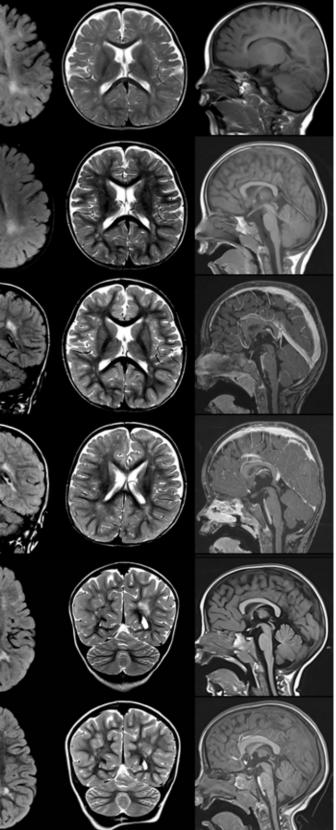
Brain MRI results obtained from seven GALNT2-CDG patients at different ages
